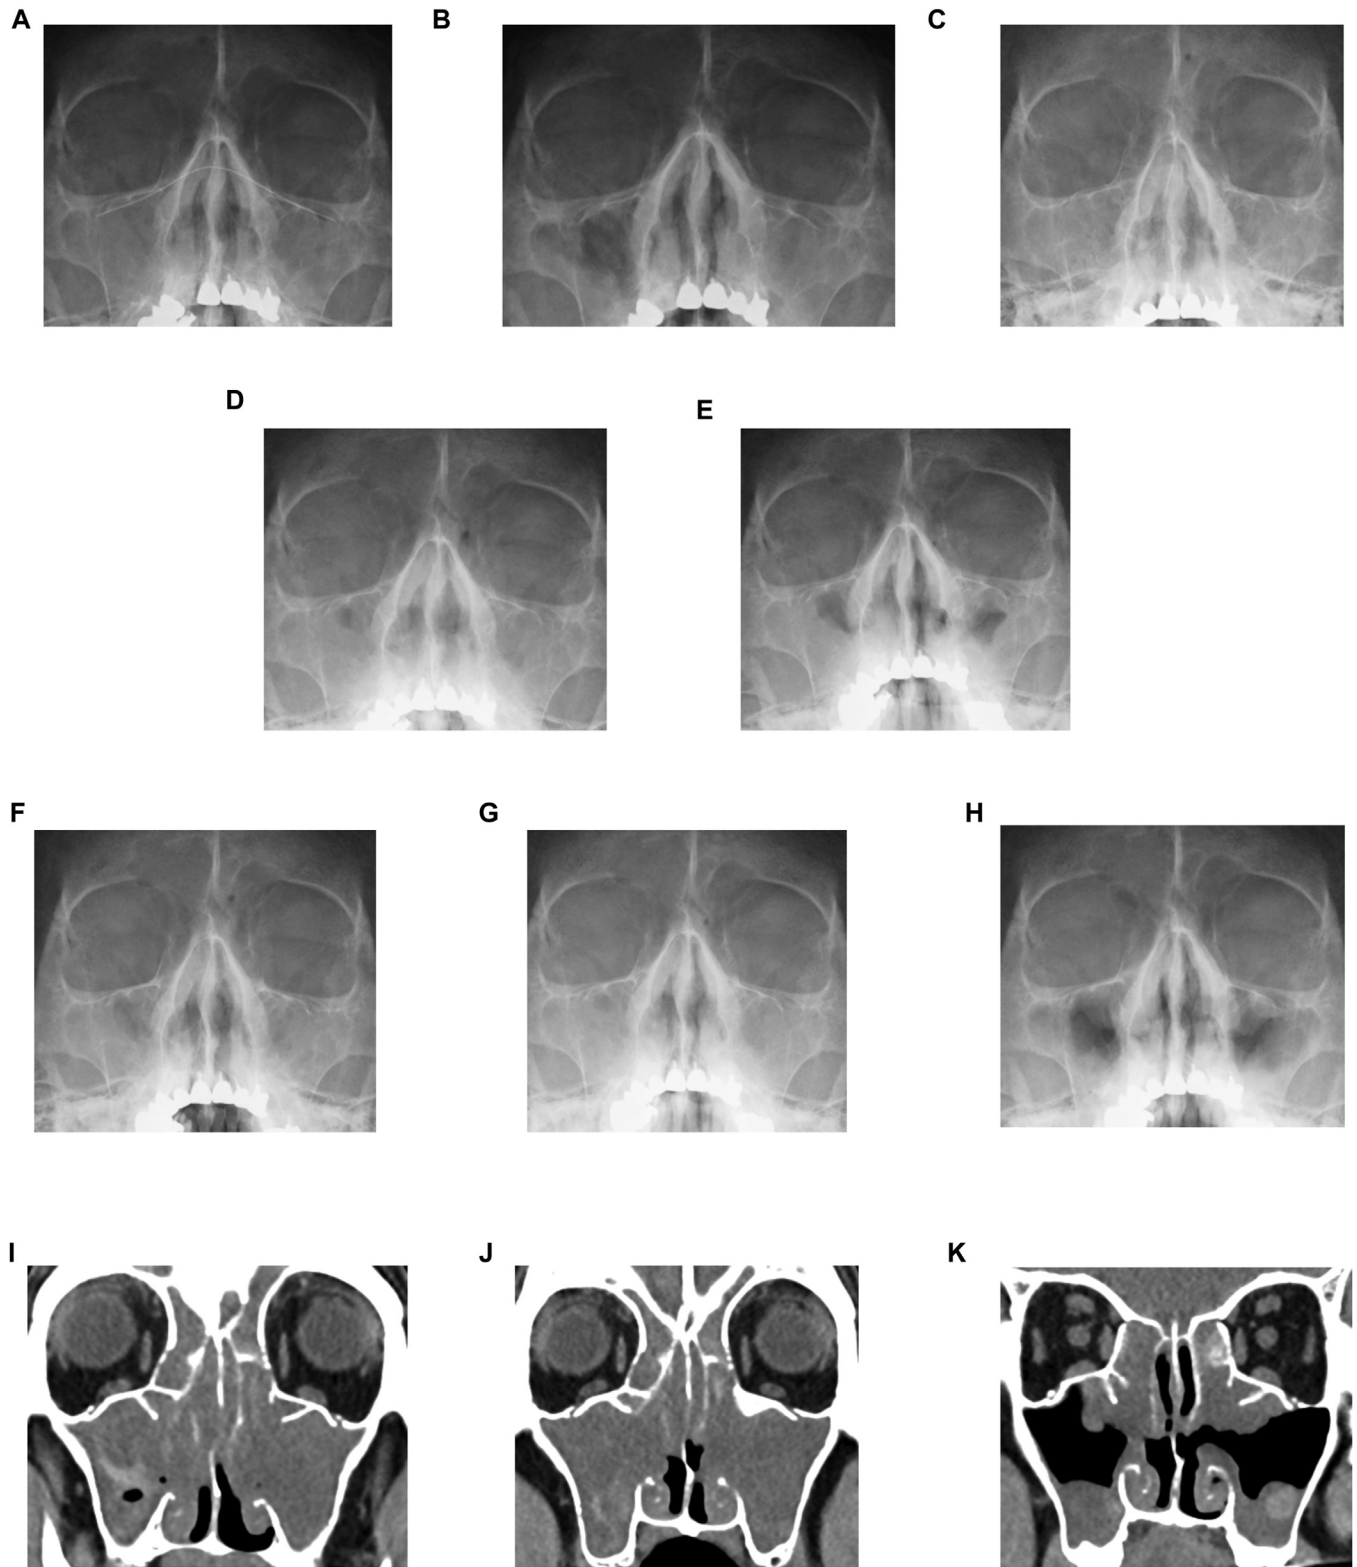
Waters radiographic views CT in case 1. A and B, Views before the start of mepolizumab administration (A) and 2 months later (B); increased permeability of the right maxillary sinus is seen. C and D, Views before the switch to dupilumab (C) and 2 weeks later (D); slightly increased permeability of both maxillary sinuses is seen. E, Five weeks after the start of dupilumab, diffusive decreased permeability in sinuses is seen. F and I, Worsening after the switch to benralizumab and soft shadow filling of the ethmoid and maxillary sinuses were seen. G, H, J, and K, After administration of tezepelumab, CT scans showed improvement of the ethmoid and maxillary sinuses.
